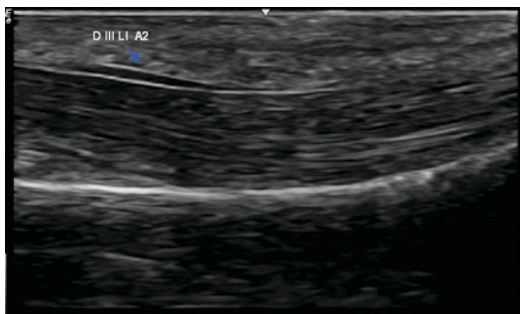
Normal A2 pulley in the ultrasound (the flexor tendon follows the course of the bone; a direct visualization of the pulley is possible)
